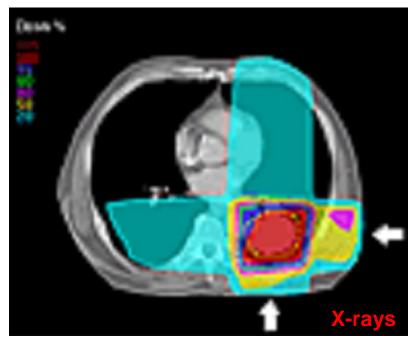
X-rays enter patient (at the arrows) & pass through the patient.
